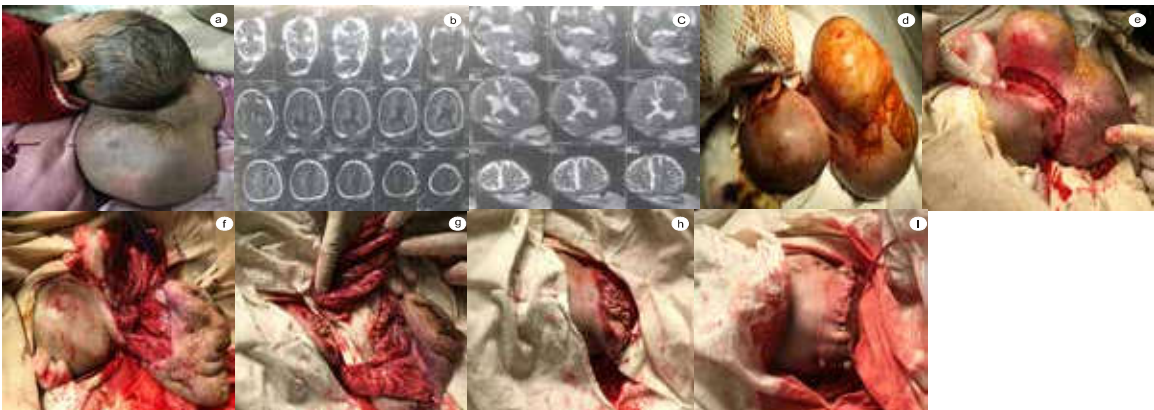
A case of 8 month old child with giant occipital encephalocele. Pre op photograph (a). MRI Brain T1 & T2 showing sac containing portion of cerebellar hemispheres (b-c). Lateral positioning of patient (d). Delineation of sac, excision of brain matter and sac (e-h). Water tight closure of dura and skin closure with drain in situ (i)..
